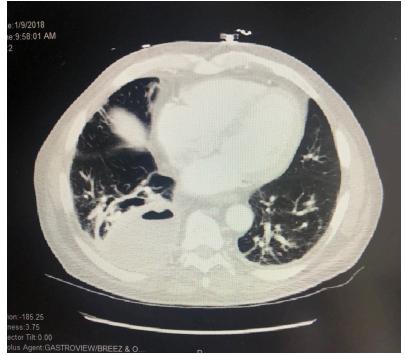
CT scan with contrast showing a right lower lung abscess.
